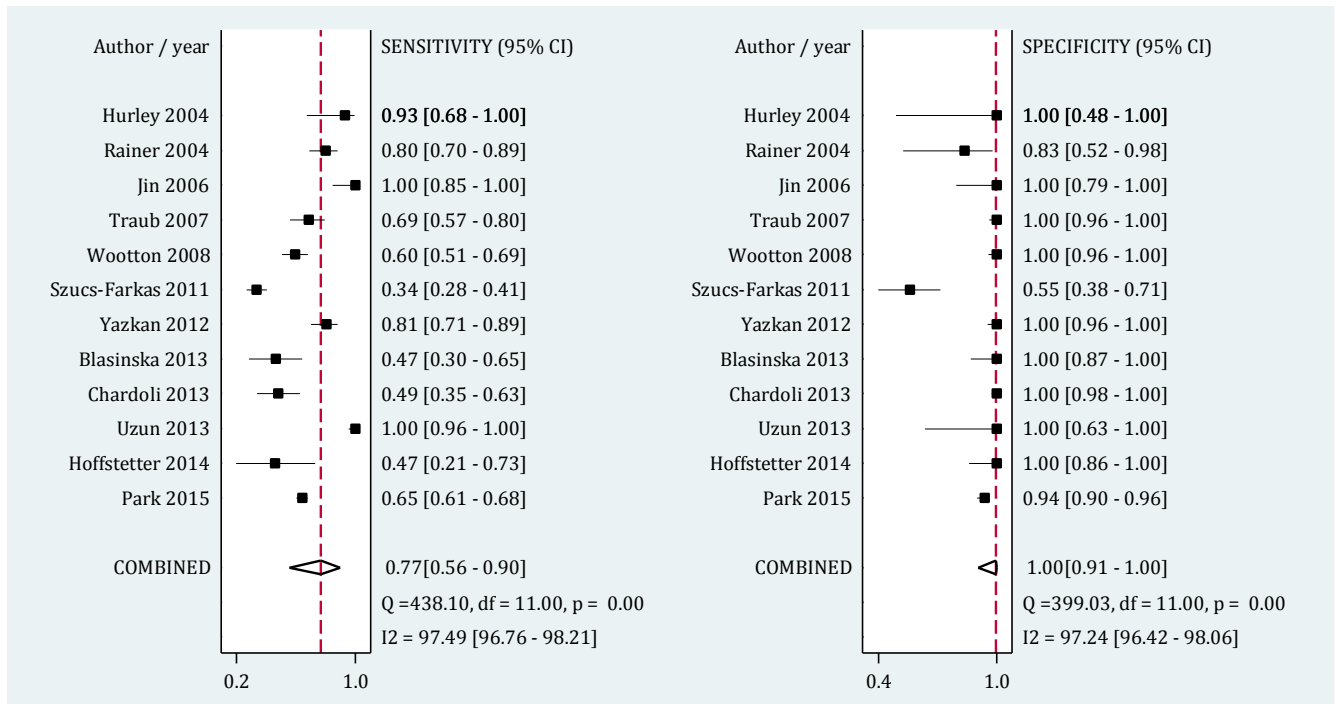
Forest plot of screening performance characteristics of chest ultrasonography in detection of thoracic bone fractures. Sensitivity and specificity (A); Diagnostic likelihood ratio (DLR) (B). CI: Confidence interval.
